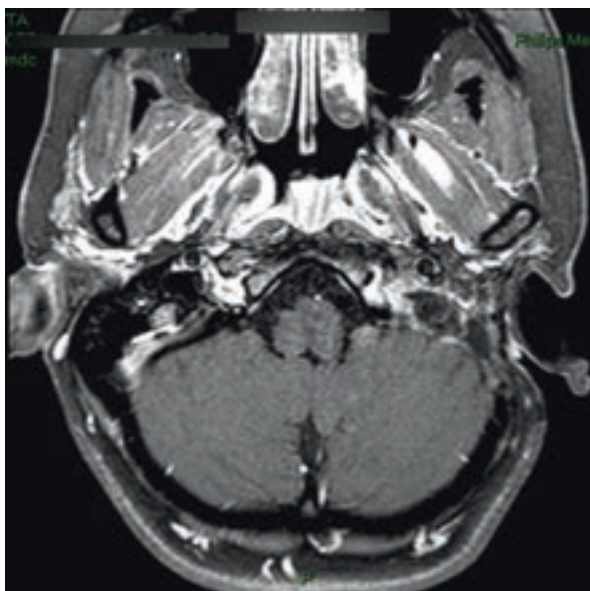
Postoperatively MRI shows complete tumor clearance
